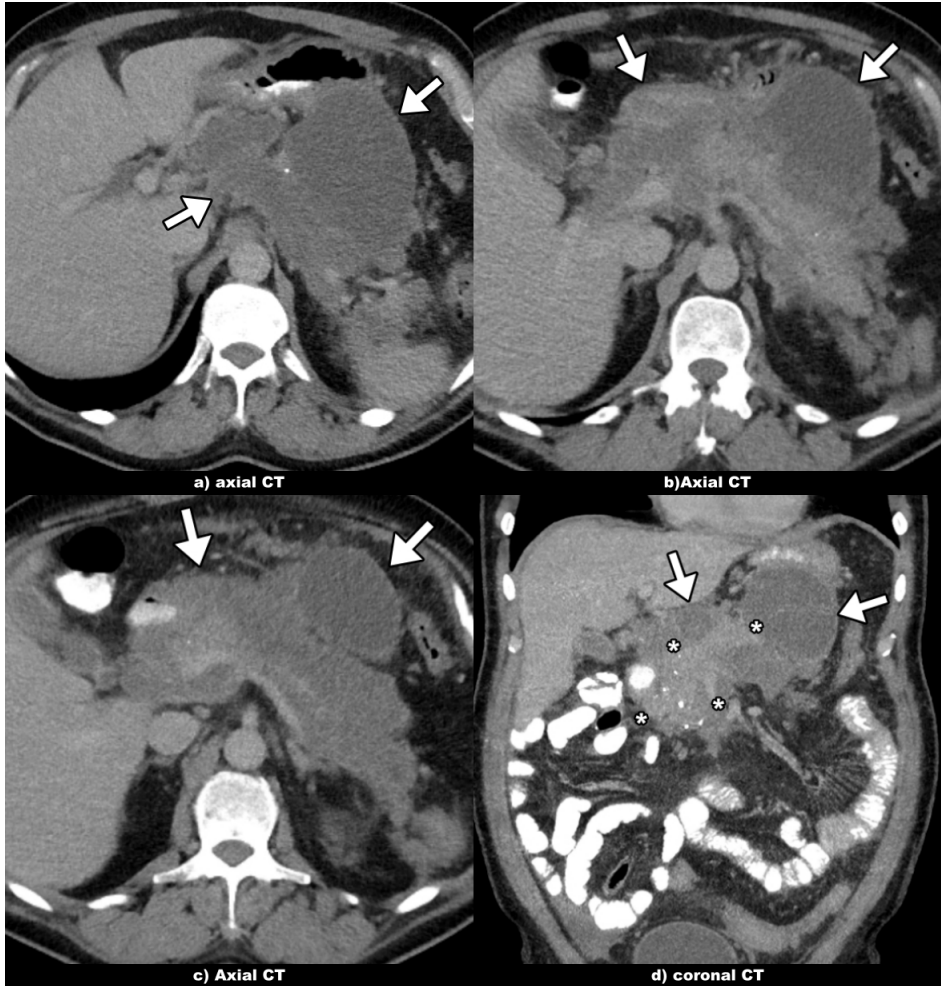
(a), (b), (c) Axial abdominal non-contrast CT images and (d) a coronal CT image of a patient with necrotizing pancreatitis. Non-contrast CT images show multiple low-density areas compatible with necrosis in the pancreatic parenchyma and multiple peripancreatic fluid collections with walls (arrows). (d) The coronal CT image shows heterogeneous pancreatic parenchyma (asterisks).
